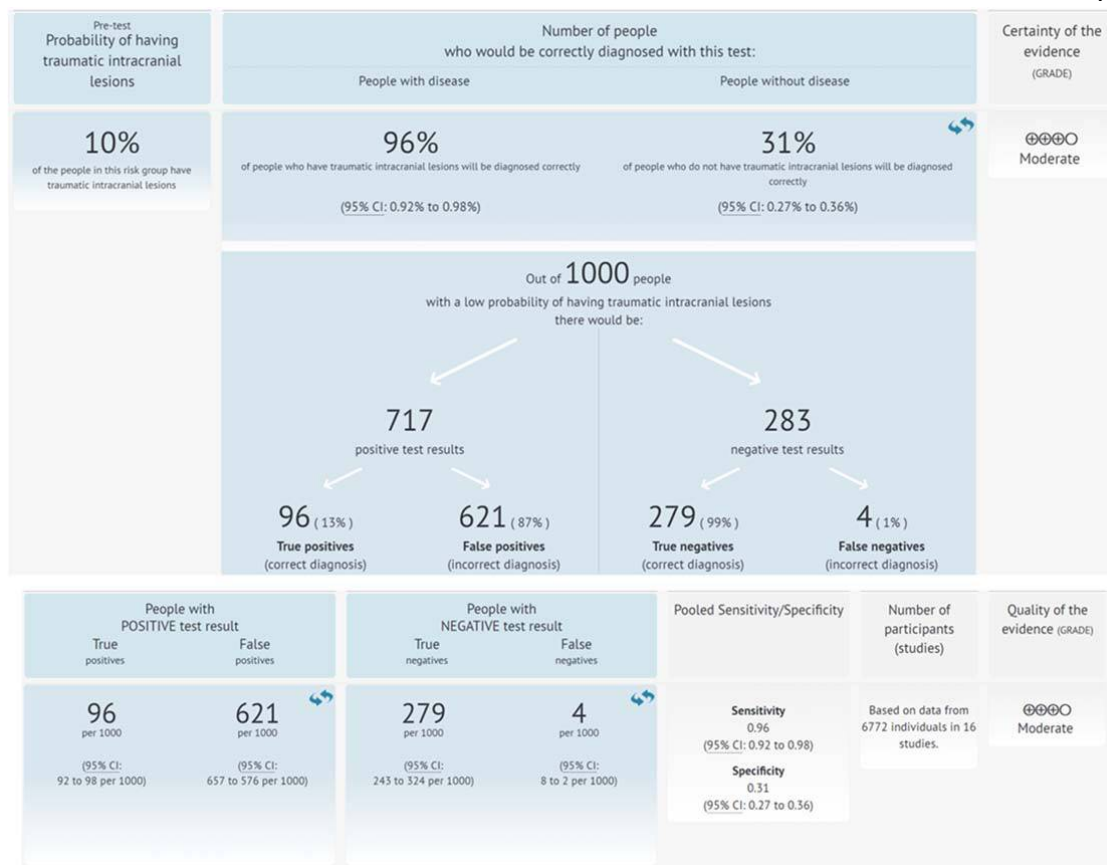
Summary of evidence for the use of blood S100B protein concentrations (0.1-0.11µg/L cut-off) to diagnose brain injury as assessed by CT scan in patients with mild TBI.
